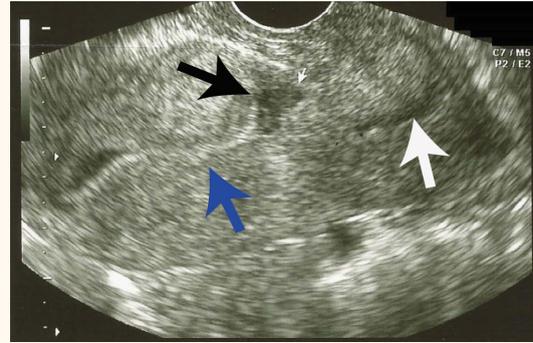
Vaginal ultrasound of an empty endometrial cavity (blue arrow) and cervix (white arrow) with a pregnancy at the Caesarean scar site (black arrow).
